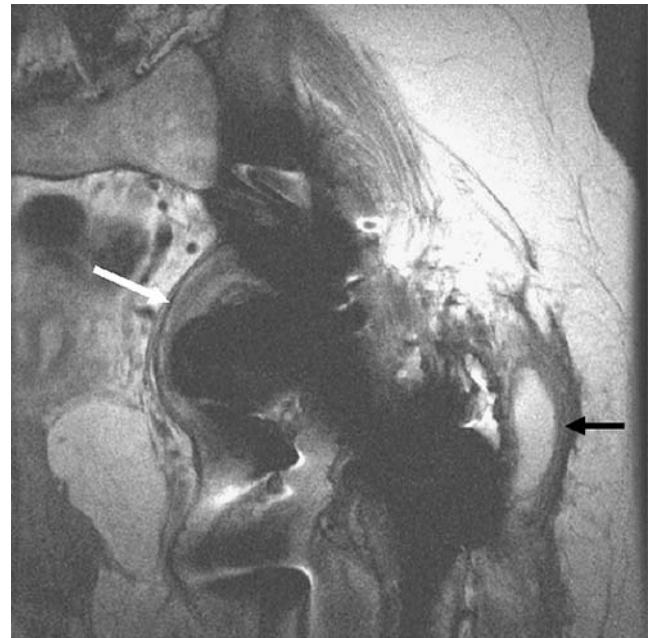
42-year-old female status post revision hip arthroplasty. Coronal fast spin-echo MR image is diagnostic in spite of the presence of metal backing and nonspherical hardware. Osteolysis is seen in the medial acetabular wall (*white arrow*) in addition to moderately severe greater trochanteric bursitis (*black arrow*)
